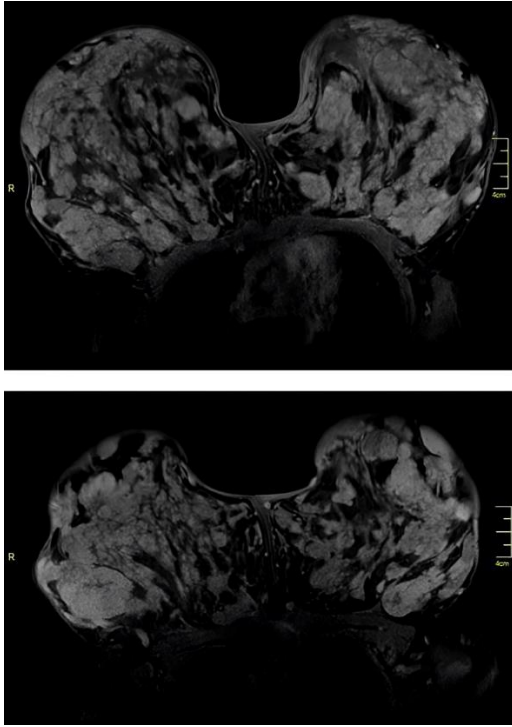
Axial gadolinium enhanced MR images of both breasts show bilateral breast hypertrophy (reprinted with permission of the patient)
